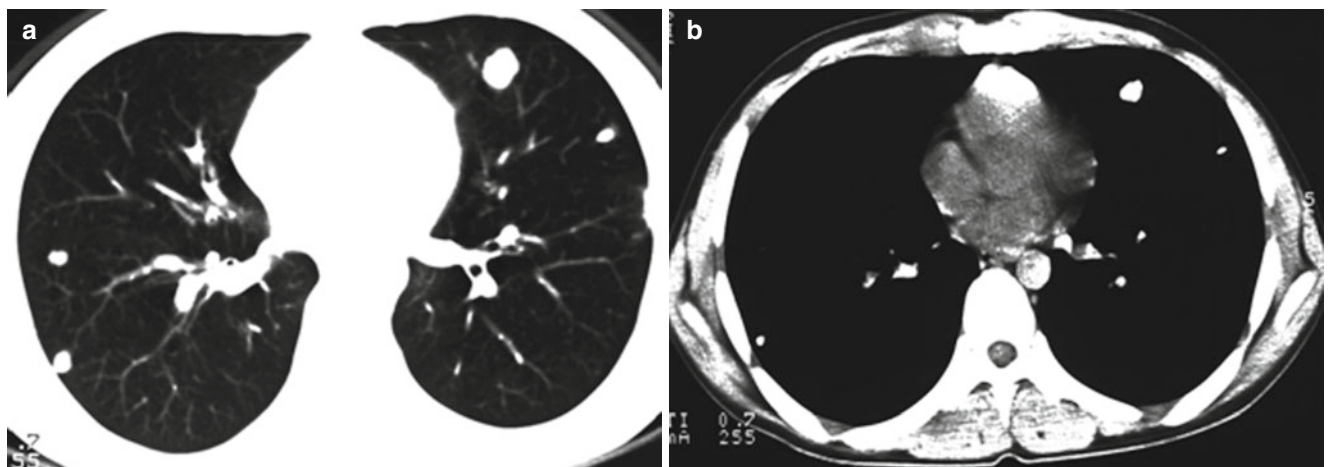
Pulmonary metastases in a 14-year-old boy with known osteosarcoma. (a, b) Nonenhanced CT with lung (a) and mediastinal window (b) shows multiple well-defined calcified nodules, usually occurring in the peripheral areas of the lower lobes
